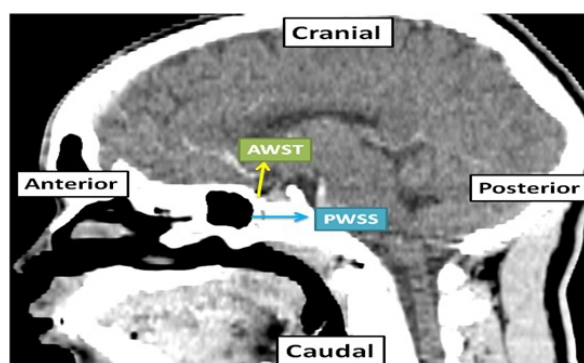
A sagittal CT slide of sphenoid sinus of a 42-year-old male showing presellar pneumatization. AWST = Anterior Wall of Sellar Turcica, PWSS = Posterior Wall of Sphenoid Sinus
